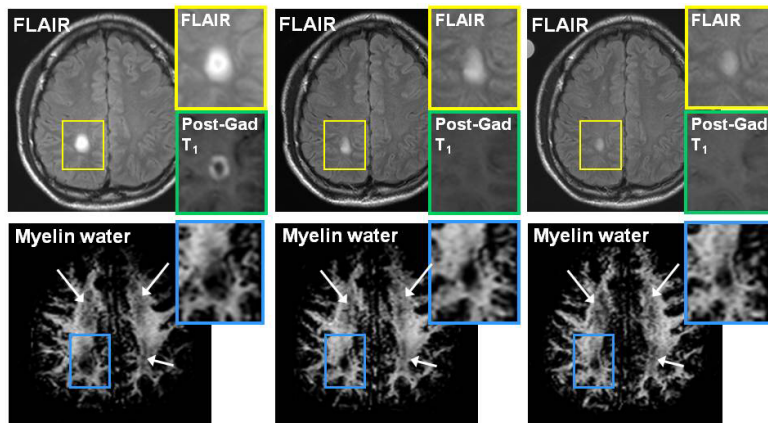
Box highlights changes in a gadolinium-enhancing lesion from month 0 to 2. Arrows show diffusely abnormal white matter with reduced myelin water, not visible on conventional MRI.
